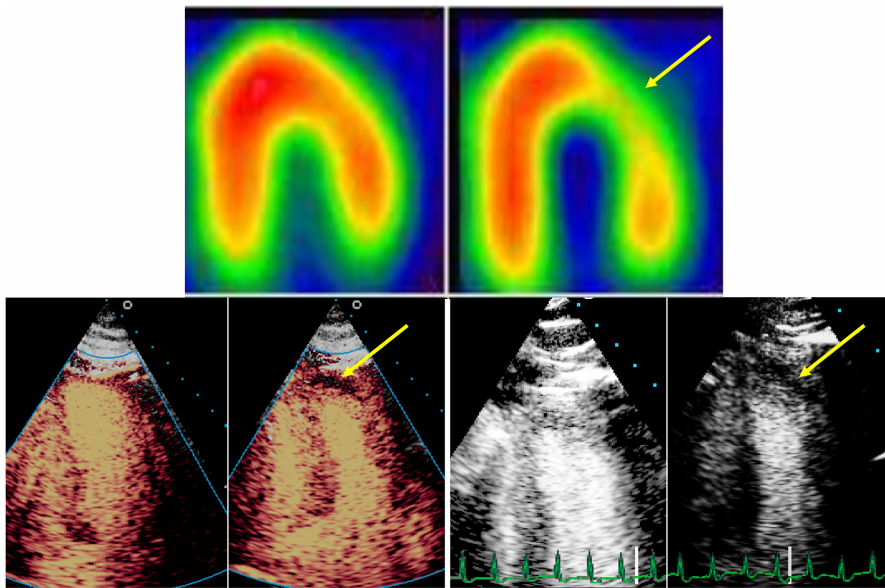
Patient with apical, anterior perfusion defect at stress (arrows), not present at rest (corresponding left image) in AM (left), HR (right) and SPECT (top).
